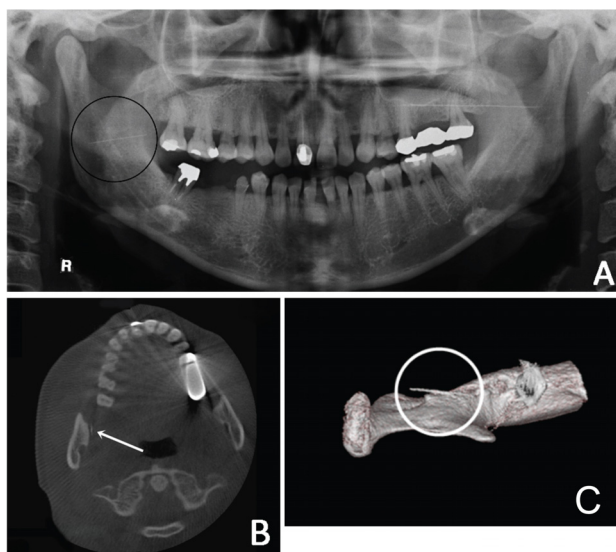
Preoperative radiographic images showing the broken needle in (A) panoramic view, (B) computed tomography (CT) axial view, and (C) as a 3D-CT image.
